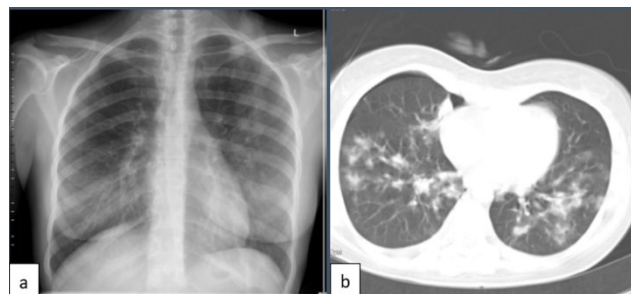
(a) Chest x-ray shows bilateral nodular opacities. Likewise, (b) chest CT scan shows bilateral multifocal nodular infiltration
